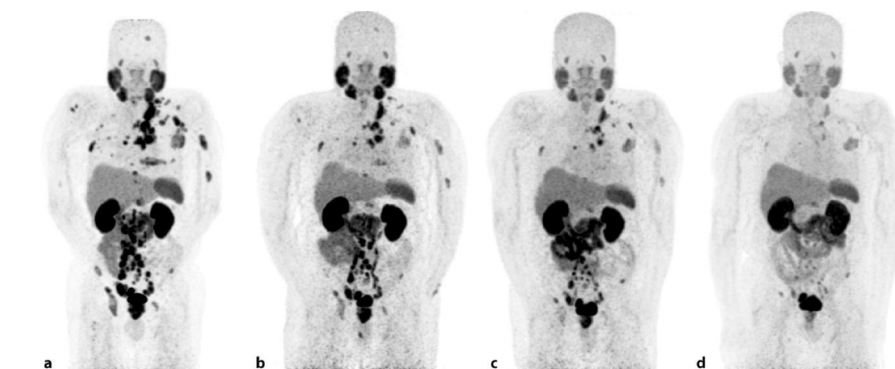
<sup>68</sup>Ga-PSMA PET scans of a patient with mCRPC. (a) Baseline, PSA 100µg/L; (b) After 2 cycles of <sup>177</sup>Lu-PSMA, PSA 190µg/L; (c) After 4 cycles of <sup>177</sup>Lu-PSMA, PSA 52µg/L; (d) After 6 cycles of <sup>177</sup>Lu-PSMA, PSA 19µg/L. - Tijdschr Urol 2020; 10: 141-146.
